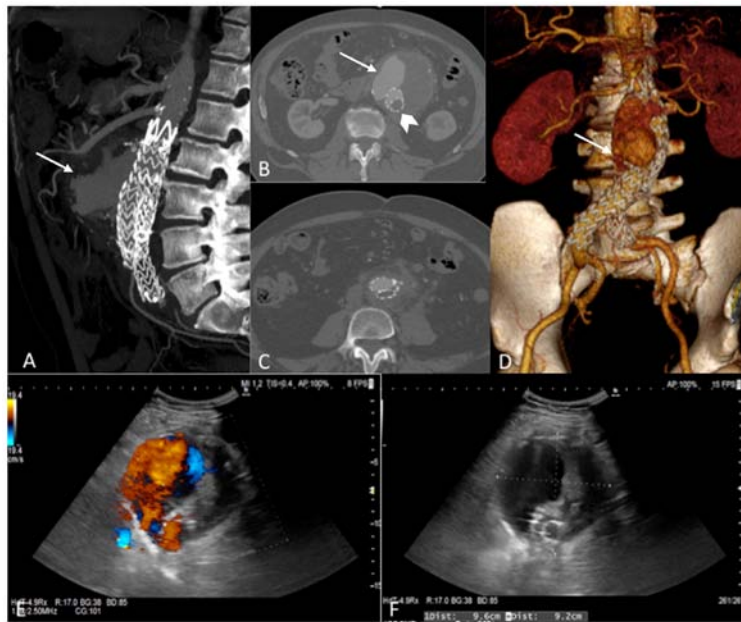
Preoperative computed tomography angiography (CTA) showing (A-D) perfusion of the sac due to type Ia endoleak (white arrows) and left limb occlusion (arrowhead). (E and F) Preoperative duplex ultrasound also showing the huge aneurysm with high-flow endoleak.
